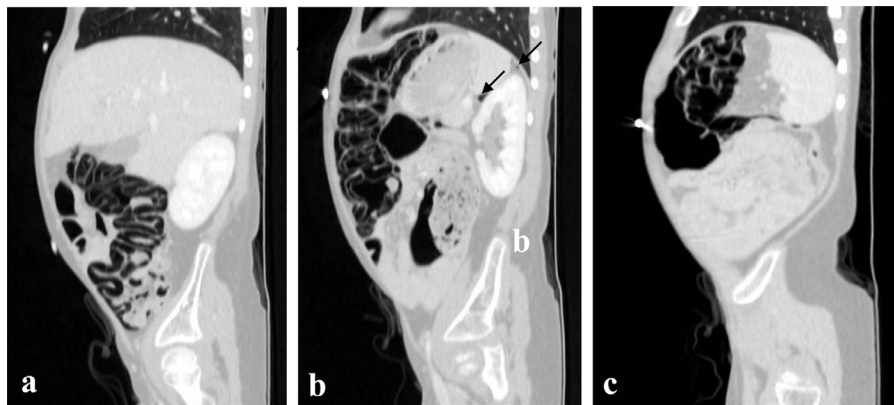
Sagittal reconstruction of abdomen contrast-enhanced CT images in lung window shows the presence of pneumatosis cystoides intestinalis of the cecum (A), ascending (A, B) and transverse colon (B, C), hepatic (A), and splenic (C) flexure and retroperitoneal free air (arrow in B).
